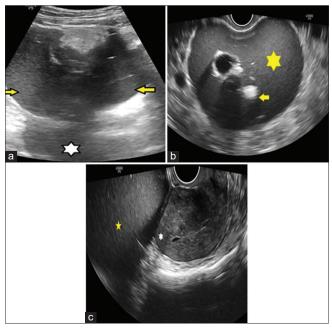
Ultrasonography (USG) images of the pelvis. (a) Gray scale transabdominal USG image of large midline placed ovarian dermoid cyst (yellow arrows), seen between anterior abdominal wall and displaced uterine fundus below (white asterisk), (b) Transvaginal USG image showing clearly the dermoid cyst (yellow asterisk) with internal echogenic fatty components (yellow arrow), (c) Transvaginal image clearly shows part of the dermoid cyst (yellow asterisk) superiorly placed to displaced uterine fundus (white asterisk)
